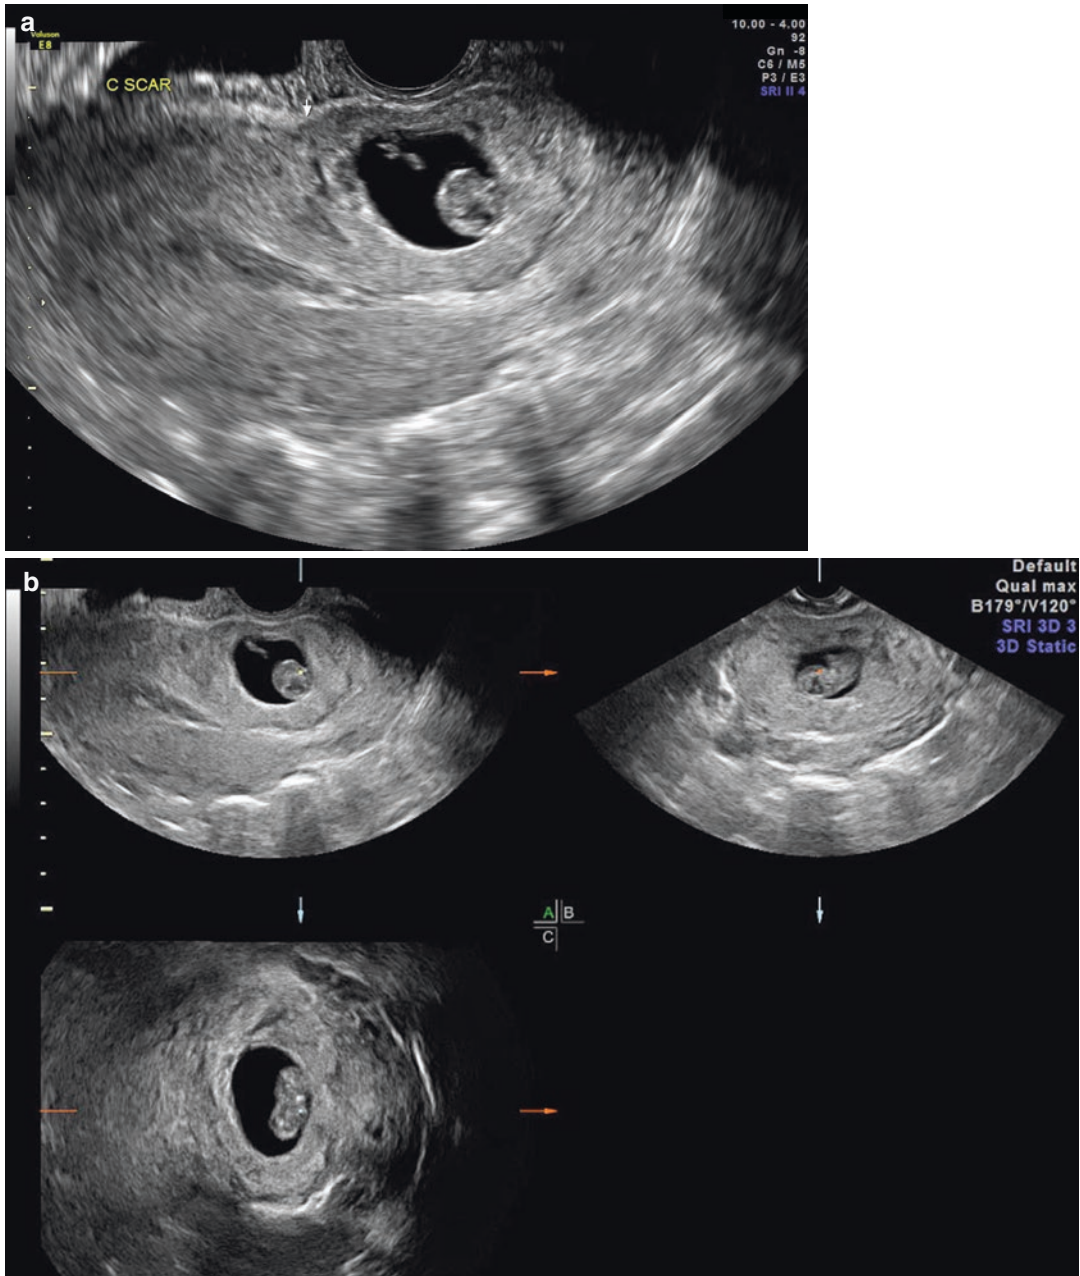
(a) Transvaginal ultrasound: midline sagittal image with gestation in the anatomical location of a prior cesarean scar. (b) Transvaginal ultrasound: 3D rendering of cesarean scar ectopic
